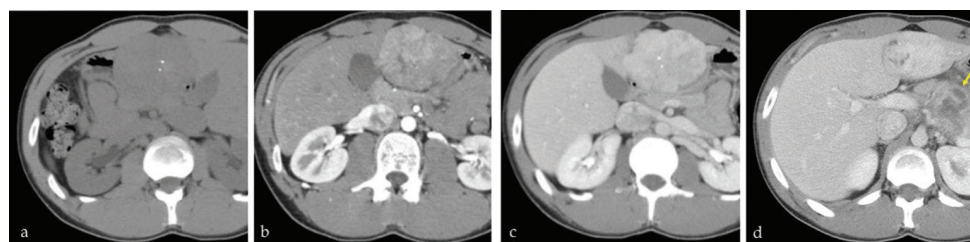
a–d. Fibrolamellar hepatocellular carcinoma on multiphase computed tomography. a. Pre-contrast image shows calcification. b. Irregular arterial enhancement without washout. c. Portal phase image shows absence of washout. d. Bulky upper abdominal lymphadenopathy (arrow).
